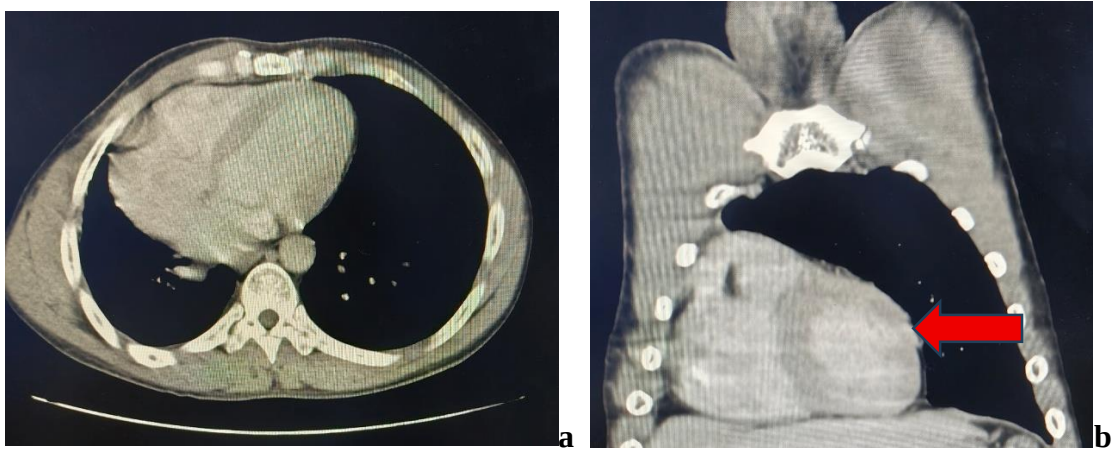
and b are axial and coronal reformatted contrast enhanced computed tomogram mediastinal window showing mediastinal shift to the right(The heart is on the right-broad red arrow).
